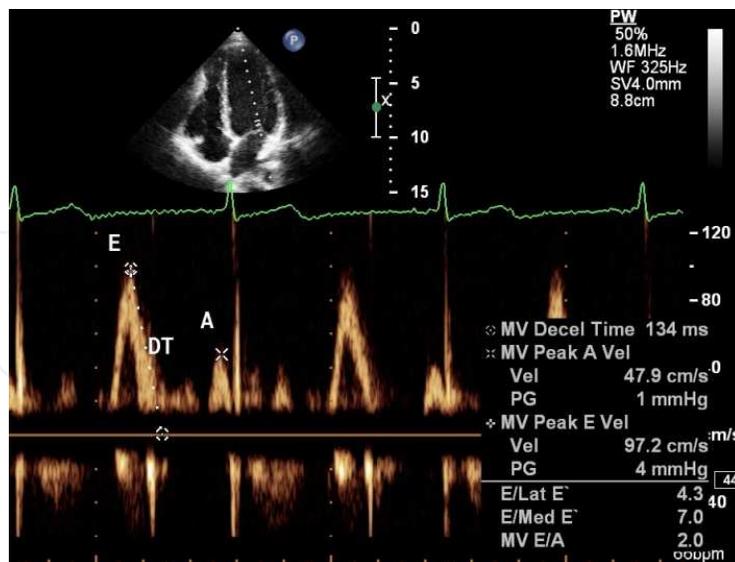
Pulsed-wave Doppler of mitral filling. E-wave - early diastolic filling, A-wave - late diastolic filling, DT - deceleration time of early mitral filling.
